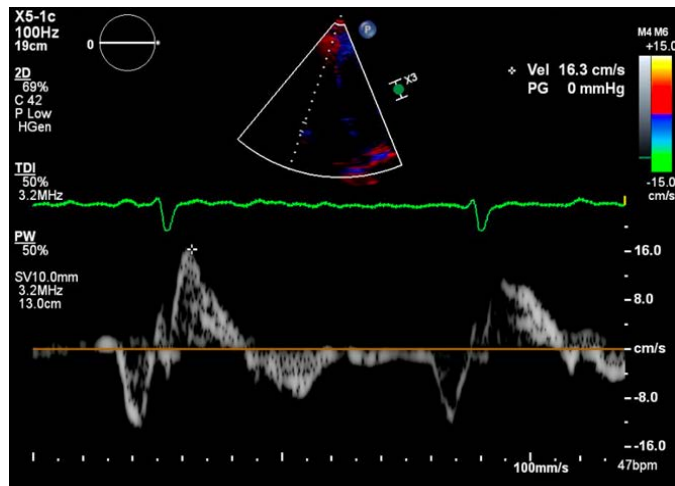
2D Echocardiogram, Tissue doppler imaging of the right ventricle.
